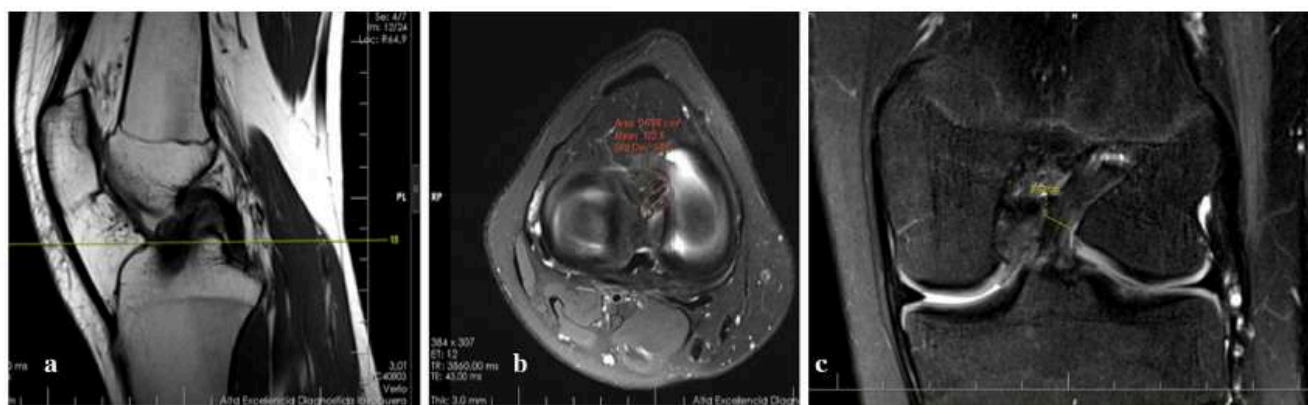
MRI study measurements. Sagittal T2 fat sat over his intercondylar path near the tibial tunnel was carried out. a Axial and coronal MRI views in the same correspondent sagittal view to define area and diameter from the graft used
